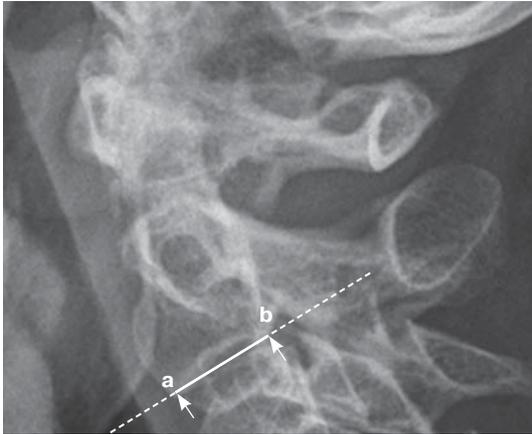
X-ray image of atlas and axis (C_1 and C_2) in sagittal projection. a is the distal point of body C_2 anterior contour; b is the distal point of body C_2 the posterior contour; ab is the absolute value of the measuring unit “órel”.
